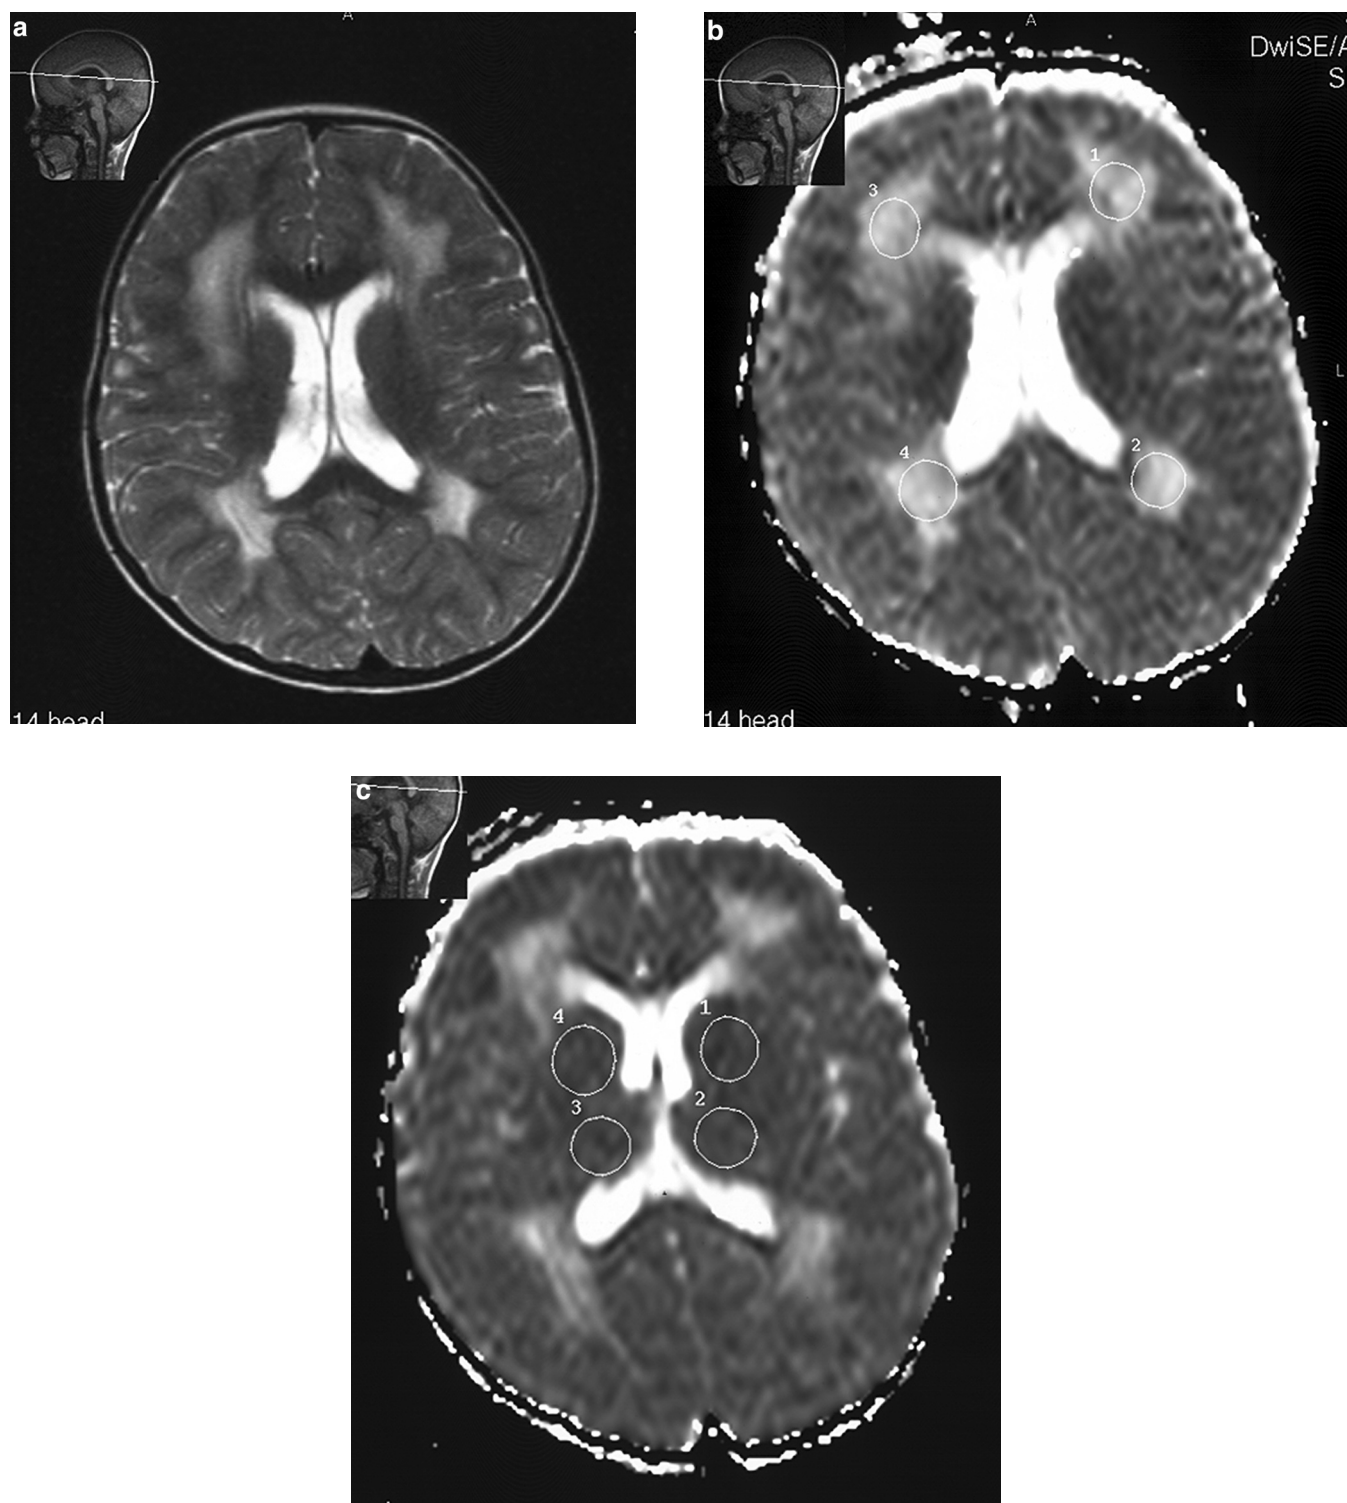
A 4-year-old girl with merosin-negative congenital muscular dystrophy. (a) Transverse T2-weighted (repetition time, 4500; echo time, 110 ms) images show high signal intensity in the frontal and parietooccipital white matters. (b) An apparent diffusion coefficient map reveals high signal intensity and apparent diffusion coefficient values in the frontal (1580 and $1600 \times 10^{-6} \text{ mm}^2/\text{s}$) and parietooccipital white matters (1630 and $1602 \times 10^{-6} \text{ mm}^2/\text{s}$). (c) Apparent diffusion coefficient maps reveal normal signal intensity and apparent diffusion coefficient values in the basal ganglia (724 , and $748 \times 10^{-6} \text{ mm}^2/\text{s}$) and thalamus (722 and $762 \times 10^{-6} \text{ mm}^2/\text{s}$).
